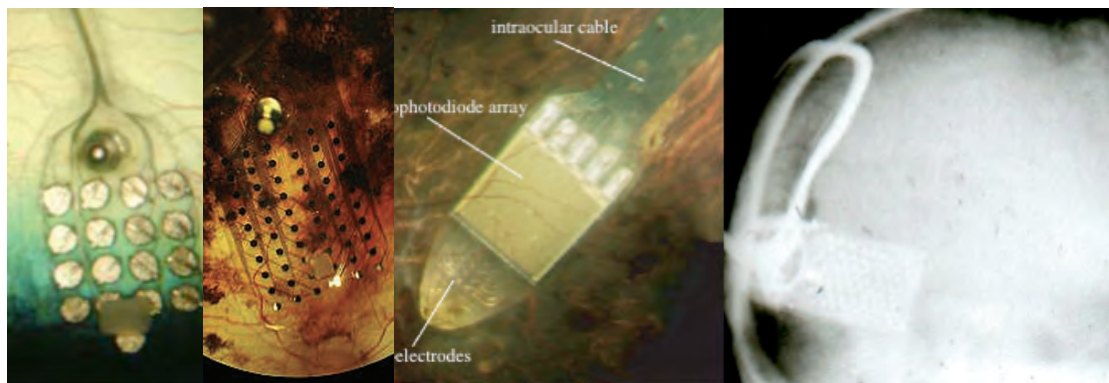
(left) Photograph of the Argus™ I and II Retinal Prosthesis System epiretinal microelectrode arrays (Second Sight Medical Products, Inc, Sylmar, CA) recently approved for use in the United States (*note increase in electrode density from 16 to 60 electrodes between Argus I and Argus II*). (center) Retinal Implant AG (Reutlingen, Germany) subretinal combined photodiode/electrode array with 1500 sensors and electrodes. (right), X-ray of implanted cortical array (Dobelle, 2000) positioned on the occipital cortex.
